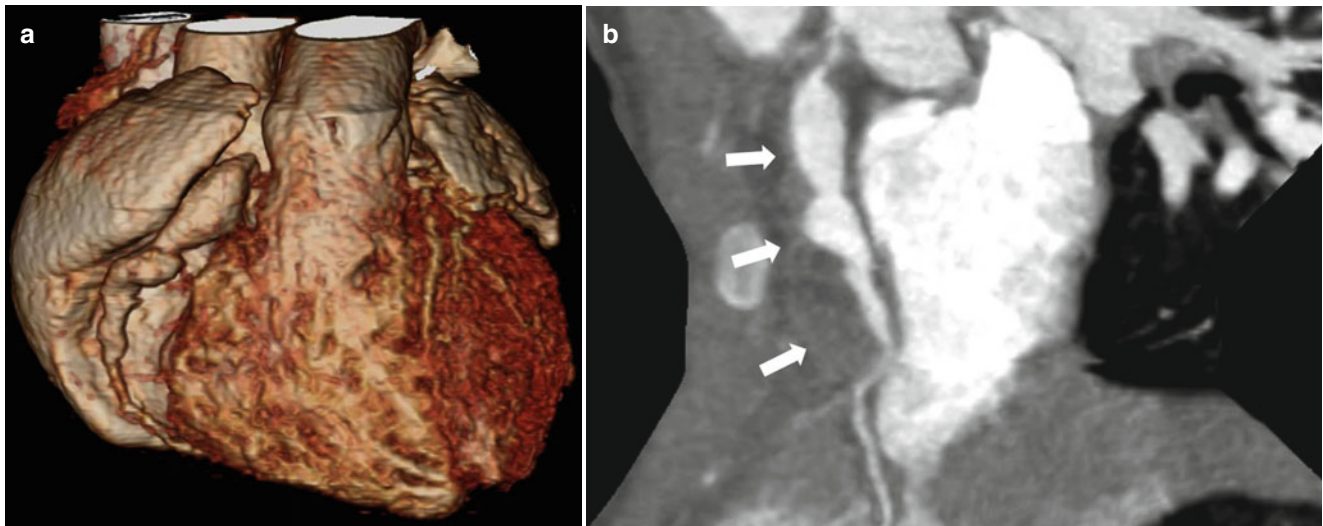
A 3-year-old girl with Kawasaki disease presenting with thrombosed coronary aneurysm. (a) 3D volume-rendering CT image shows long segmental fusiform aneurysm at the right coronary artery. (b) On curved multiplanar reformation (cMPR) image, partial mural
